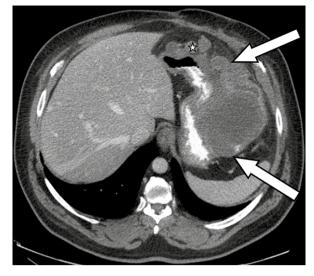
Computed tomography image of an exophytic tumor in the gastric wall (arrows). Visible metastasis in the peritoneum (\*)
